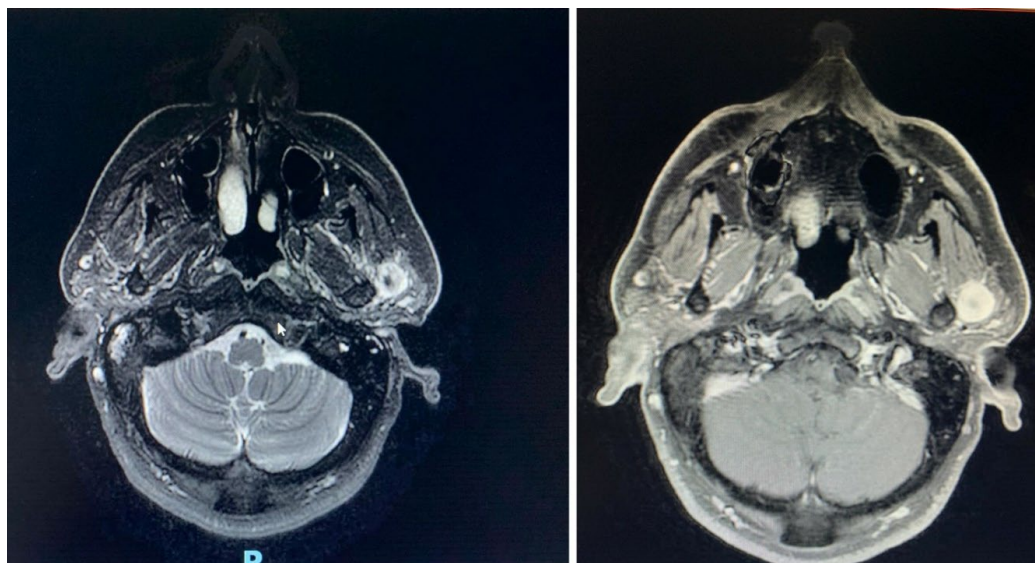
MRI of synovial sarcoma
